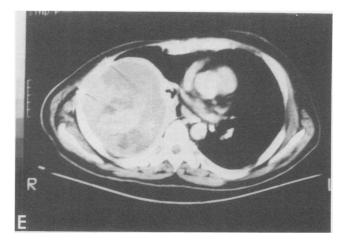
Eight months after operation a recurrence of the tumor in the right lower chest was confirmed by CT scan. The tumor can be seen extending into the right thorax.
